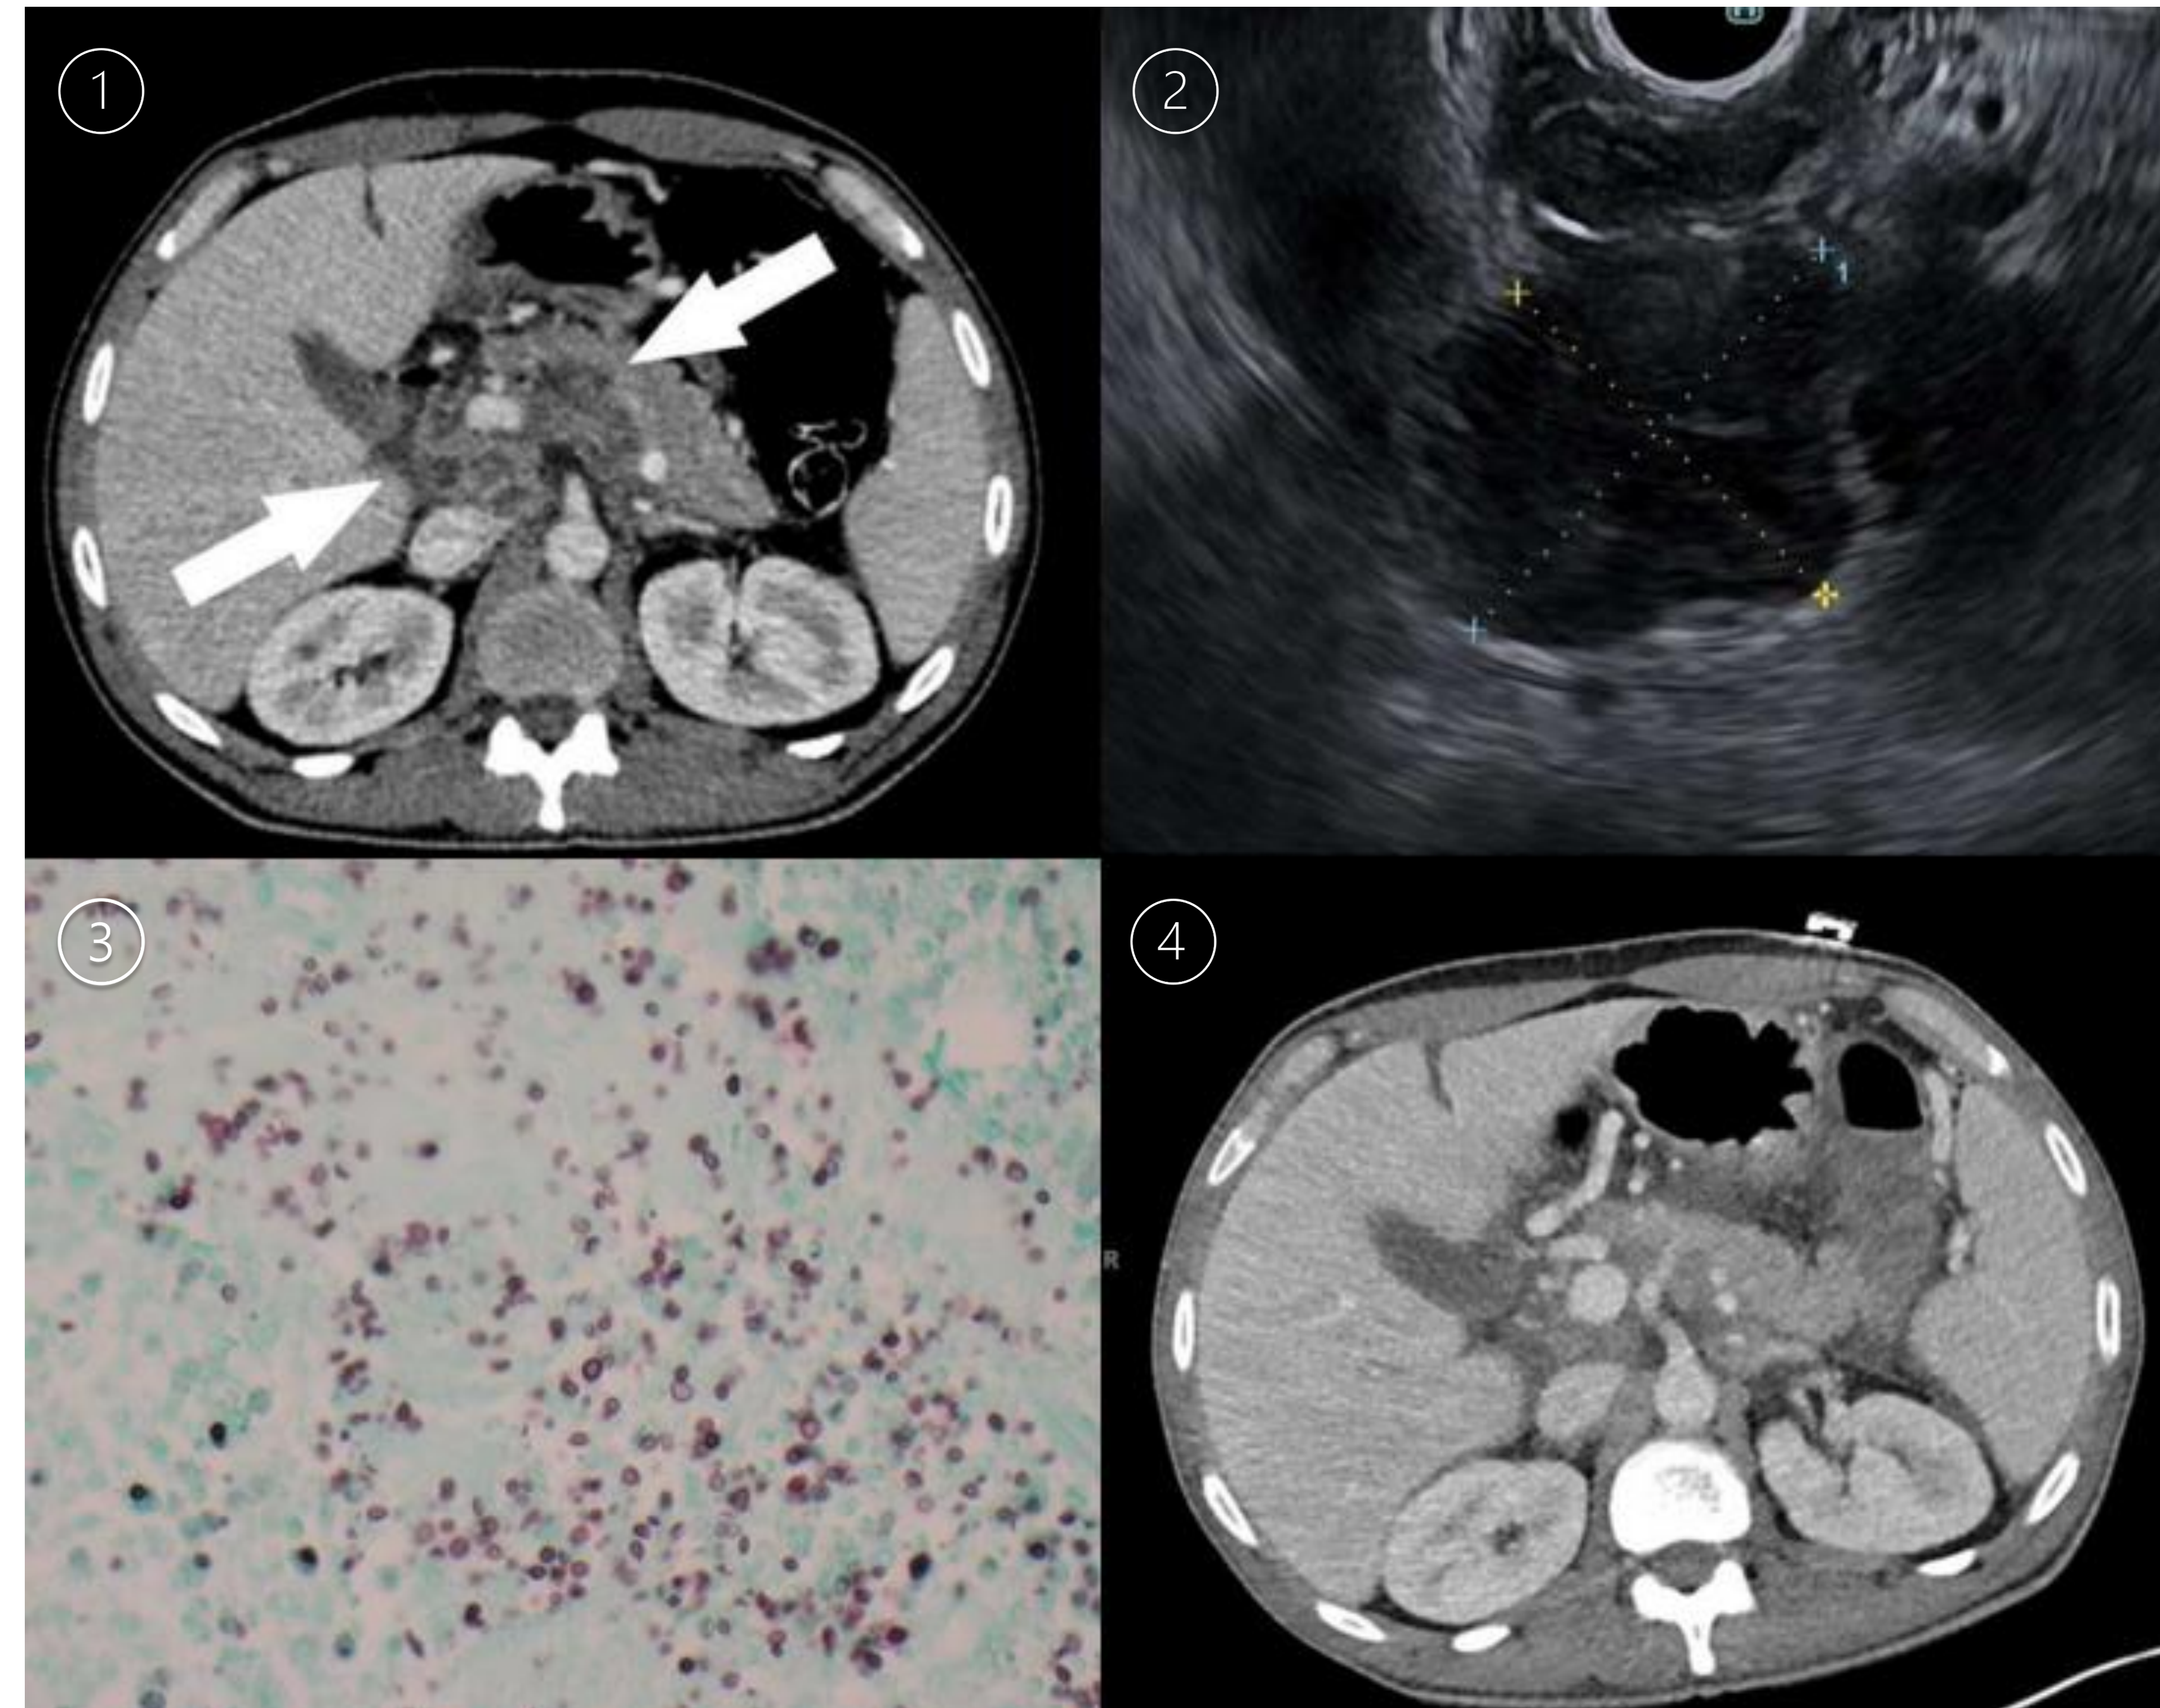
CT image showing ill-defined cystic/necrotic upper abdominal lymphadenopathy with mass effect and possible invasion of the adjacent liver
